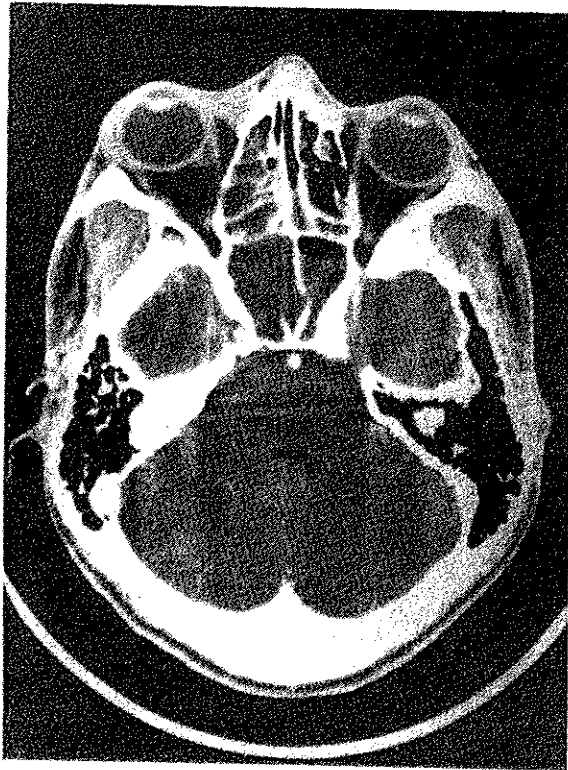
Computed tomography of the sinuses. Ethmoid sinusitis, right more than left with right proptosis.
